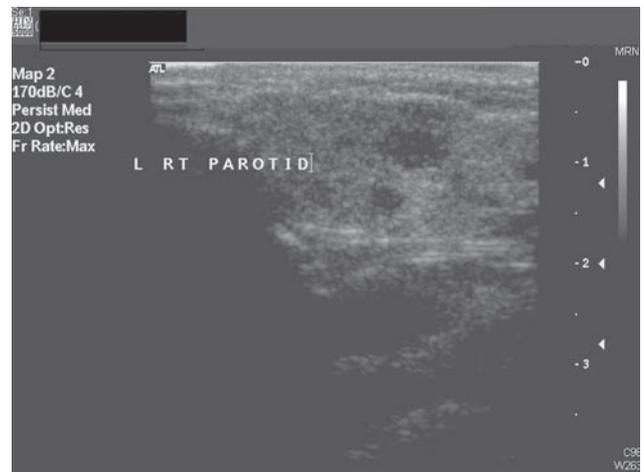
Ultrasound image of right parotid gland showing multiple hypoechoic nodules suggestive of sialectasis.
